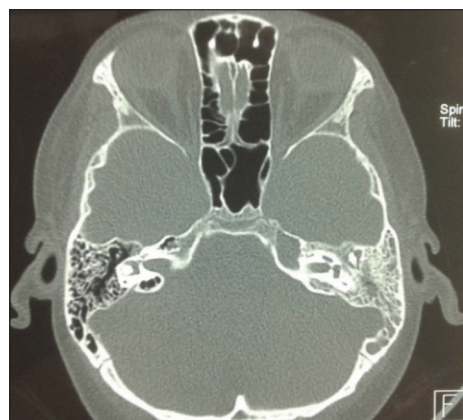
Axial computed tomography scan showed soft tissue opacity of the middle ear, mastoid and petrosal apex on the left side
